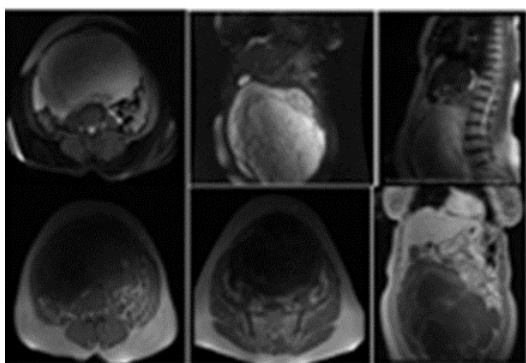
The MRI of adnexal mass.
